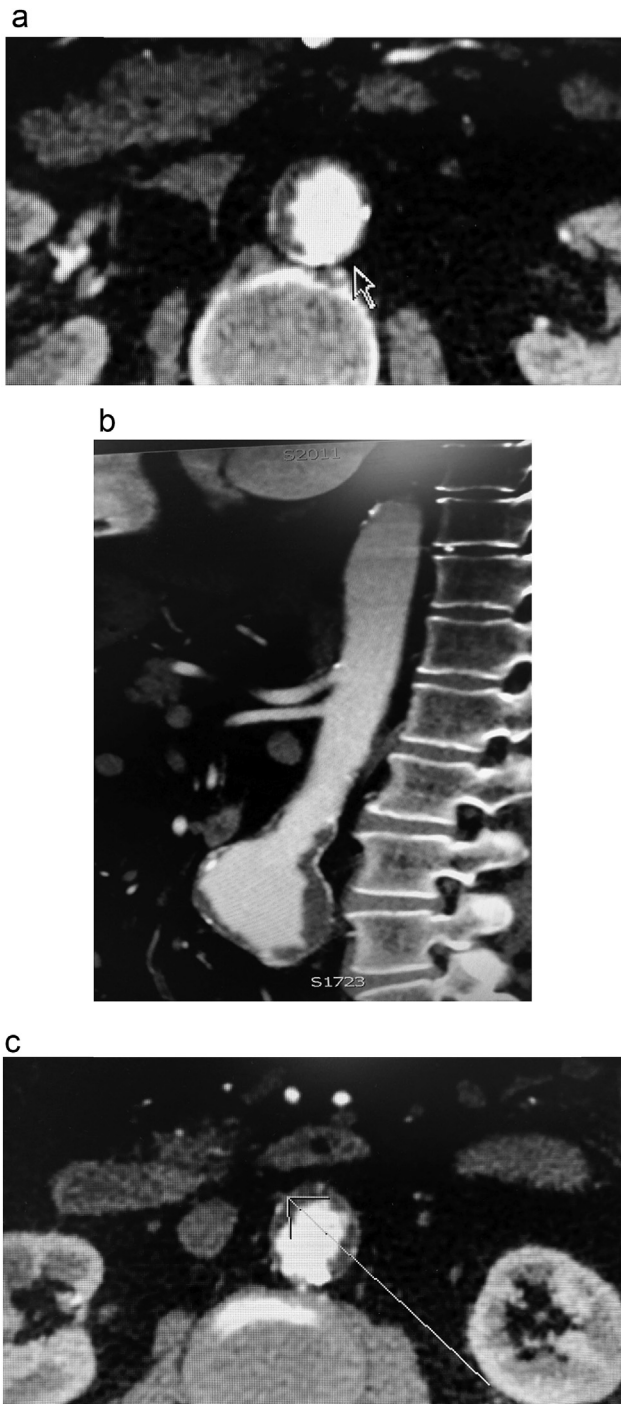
(A) Contrast enhanced computed tomography (CT) angiogram showing disease in the aortic aneurysm neck proximal to the origin of the gonadal artery. (B) Contrast enhanced CT angiogram showing thoracic aorta relatively free of disease. (C) This contrast enhanced CT angiogram shows the right gonadal artery arising from the thrombus filled aneurysm sac (shown by arrow).
